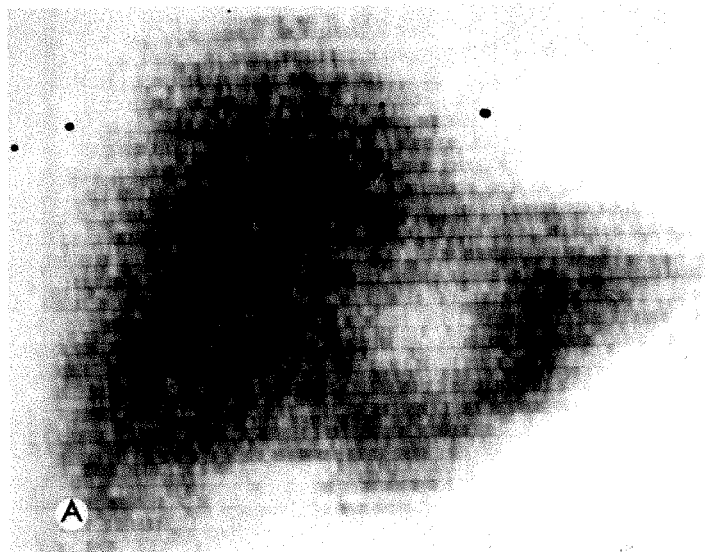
59-year-old man with renal mass. *A*, Radionuclide liver scan showing large filling defect in left lobe consistent with metastasis. *B*, CT scan showing single 3 cm sharply demarcated lesion in anterior aspect of left lobe (arrow). *C*, Measure mode with narrow window setting. Attenuation equivalent of filling defect is 3 EMI units, equal to water density. Findings diagnostic of cyst rather than metastases. Surgery disclosed benign hepatic cyst without metastases in liver and renal cell carcinoma.
